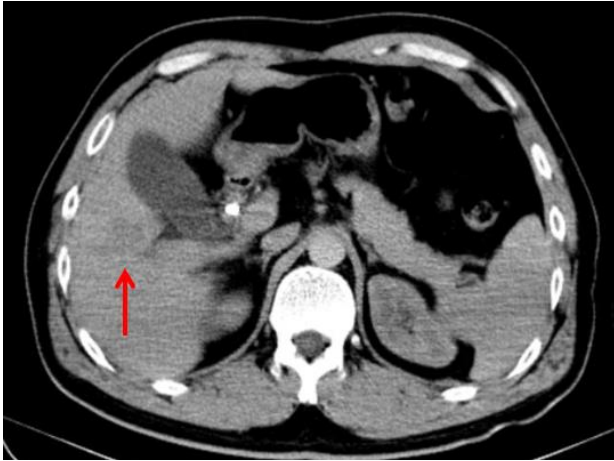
Post-treatment CT of the abdomen shows that the cyst disappeared and the biliary tract dilation improved (red arrow)
